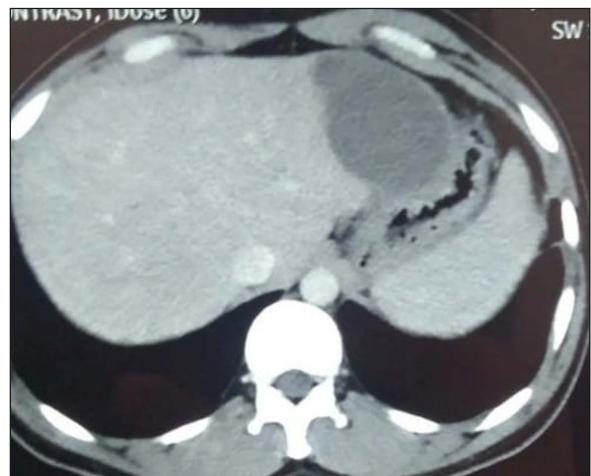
Computed tomography showing hypodense lesion in left lobe of liver.
